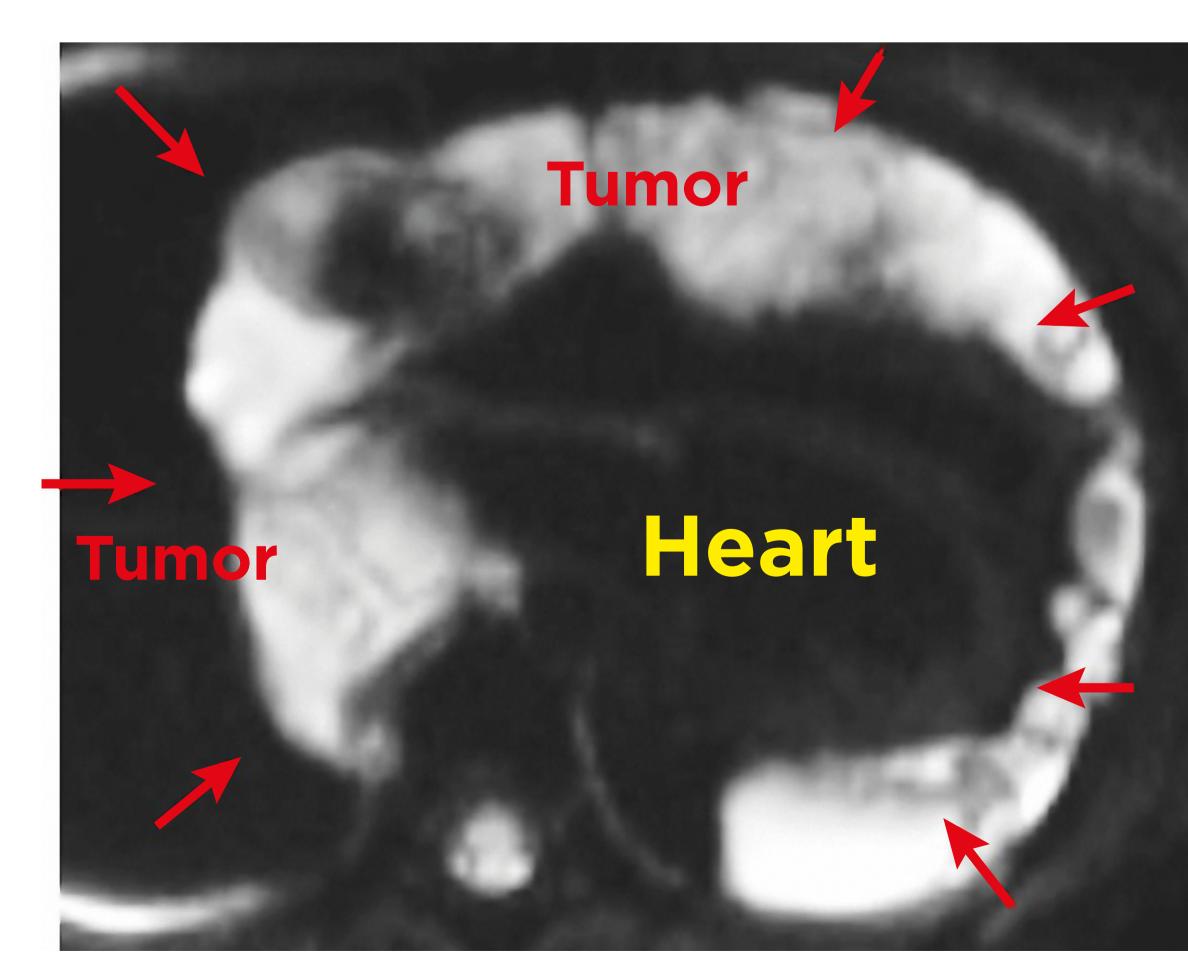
Chest MRI of the patient.
